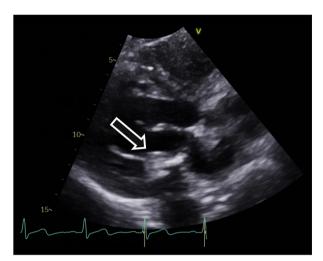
Transthoracic echocardiogram showing a 1.3-cm mobile mass in the posterior chordae, consistent with calcification.
